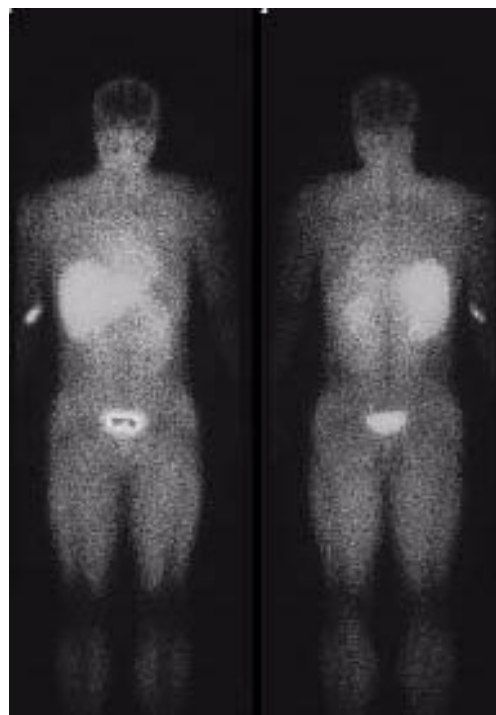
Planar scintigram of a healthy volunteer 30 min after injection of ^{123}I -IAZA (185 MBq as bolus i.v. dose). Reproduced from Stypinski 1998.
